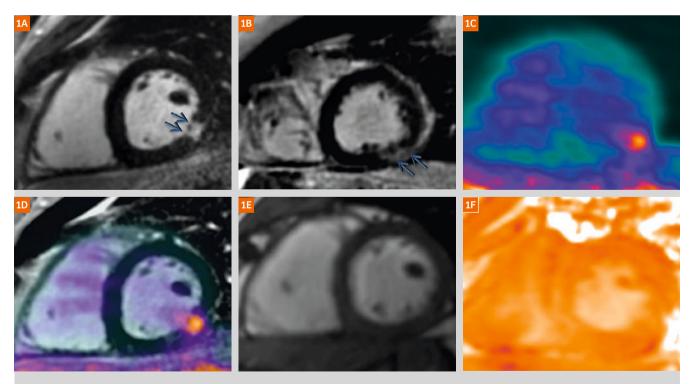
Two-chamber short-axis view of the right and left ventricles showing a discrete area of LGE in the infero-lateral wall (blue arrows) (1A-B). Focal increase in FDG nearing the inferior wall of the myocardium and adjacent to the liver as seen in the PET alone (1C). Fused FDG-PET/MR images showing increased FDG signal perfectly localized to area of LGE (1D). Two-chamber short-axis cine CMR showing mild hypokinesis of the infero-lateral wall (1E). Native CMR T2 mapping (1F).
